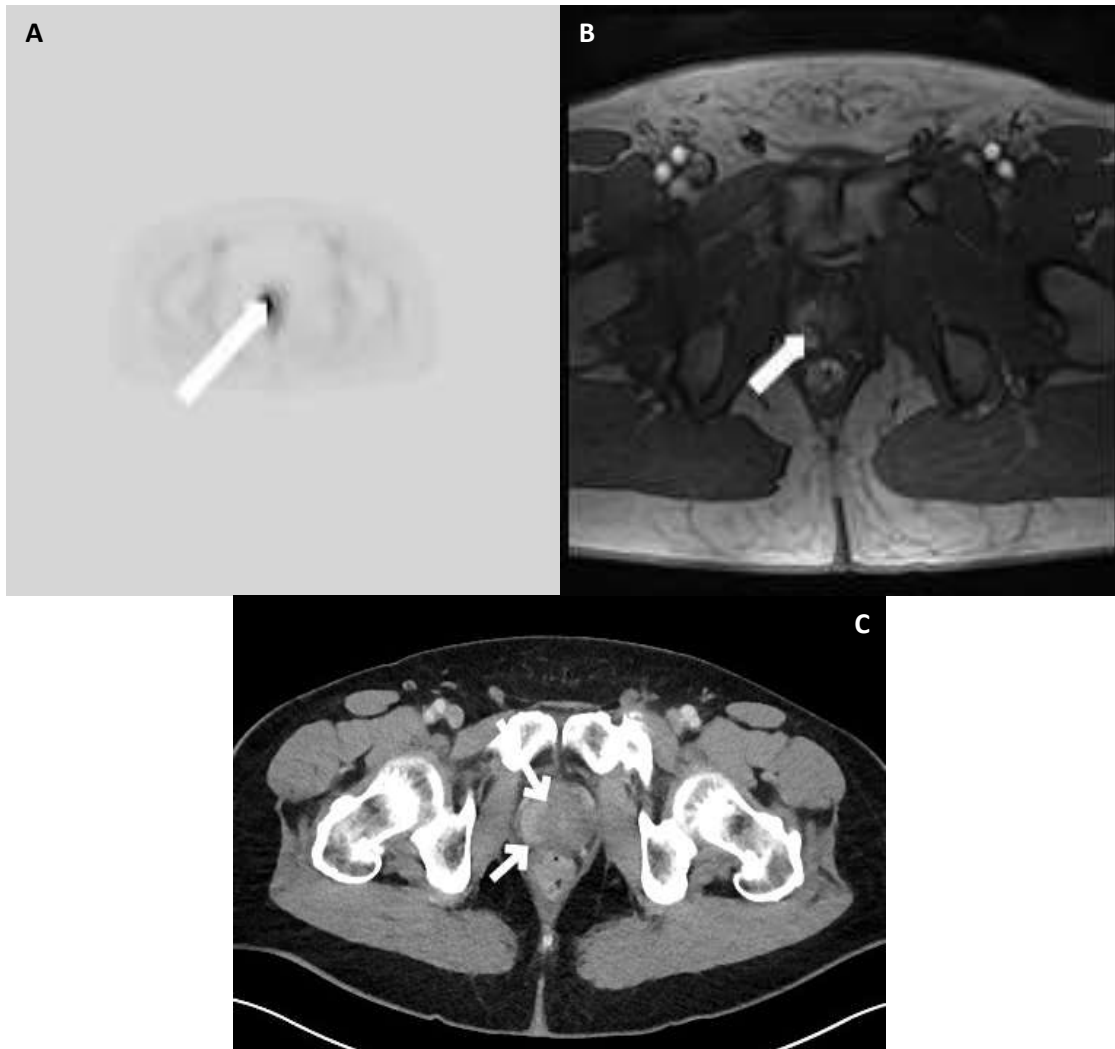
Right iliac nodal recurrence demonstrated in patient BCR017; (A) PSMA PET MRI demonstrating PSMA avid right iliac node (B) Right iliac node on T2 weighted MRI (white arrows).
